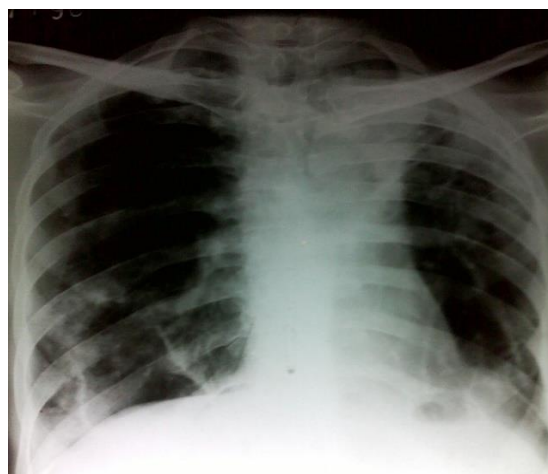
Chest X-ray PA view showing a well-circumscribed, oval, mass like lesion in the right mid and lower zone abutting diaphragmatic outline
